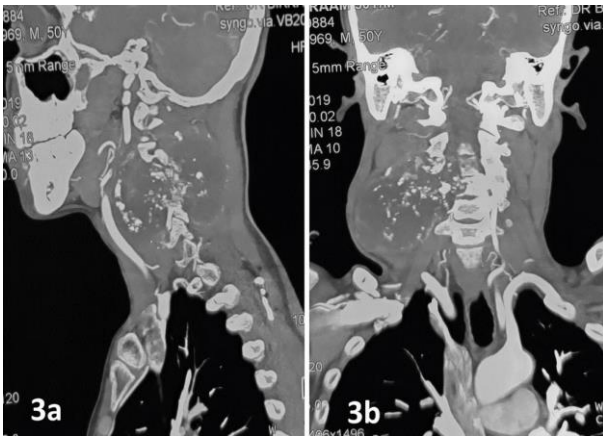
Preoperative computed tomography angiography (a) sagittal view shows mottled calcification within large osteolytic lesion with anteriorly displaced carotid artery; (b) coronal view shows dominant left vertebral artery without visualization of right vertebral artery with partial destruction of multiple vertebrae.
